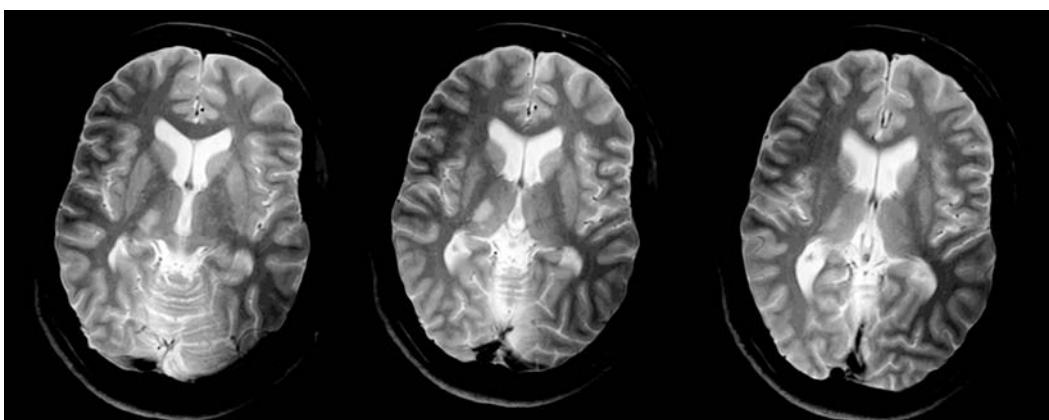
Three successive scans of patient KE [MRI T2/ FLAIR] MRI, magnetic resonance imaging.
